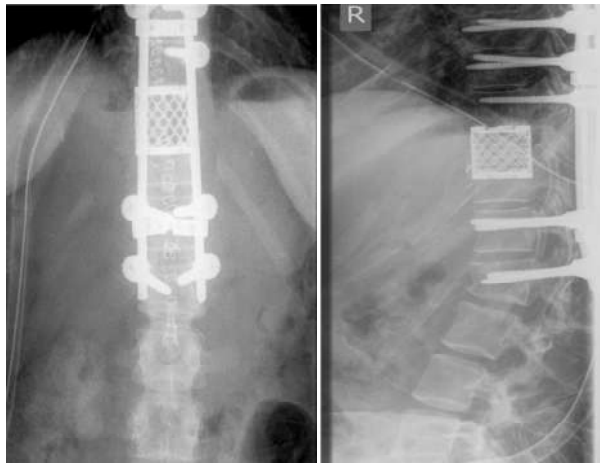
AP (left) and lateral (right) X-ray showing post-operative anterior and posterior instrumentation
